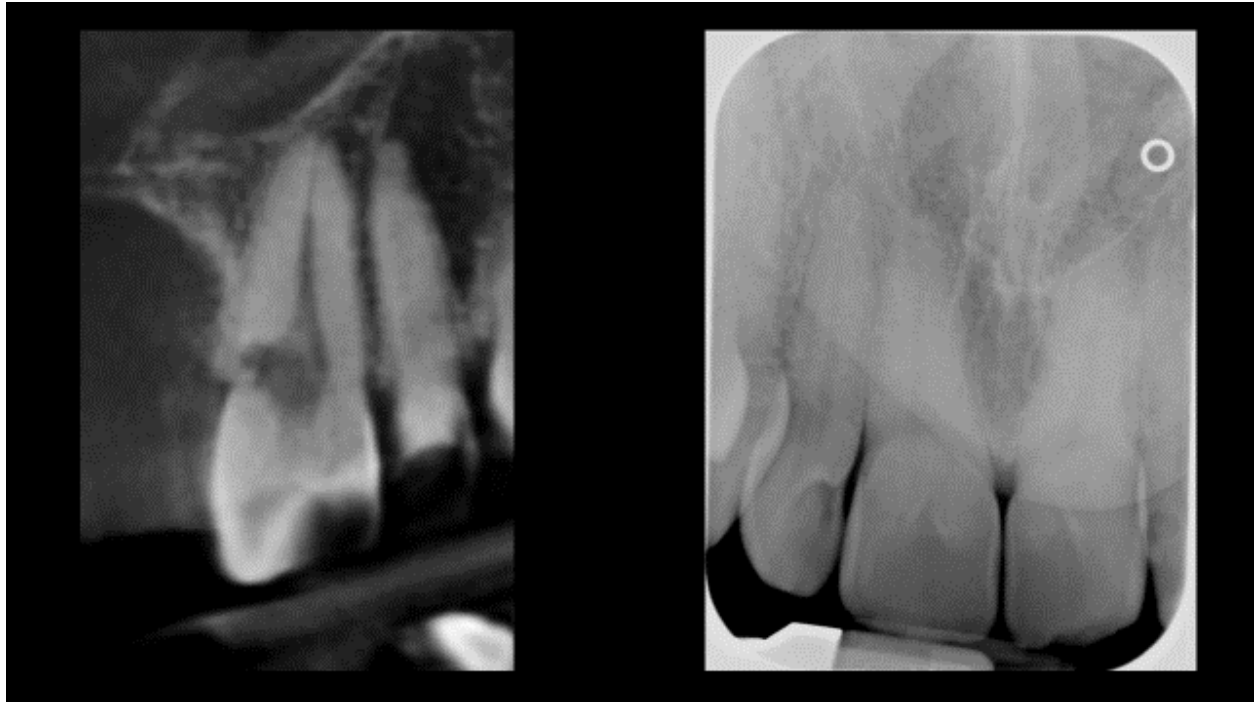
Internal root resorption #9 CBCT (left) not visible on PA (right)
